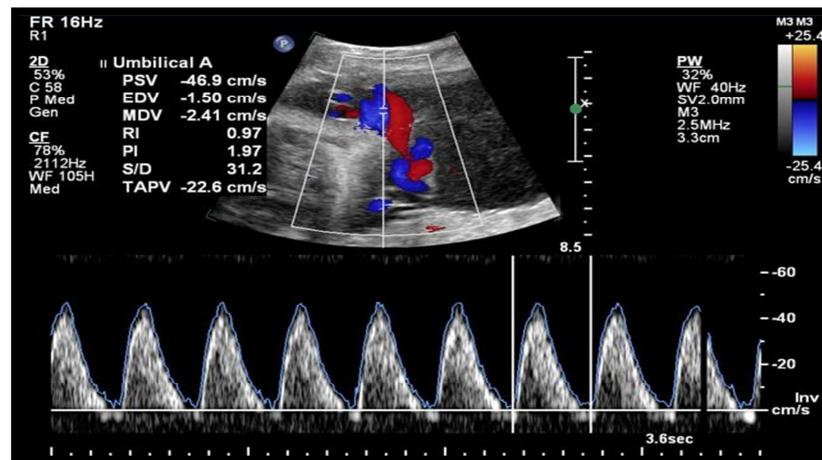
DOPPLER SHOWING REVERSAL OF EDF
